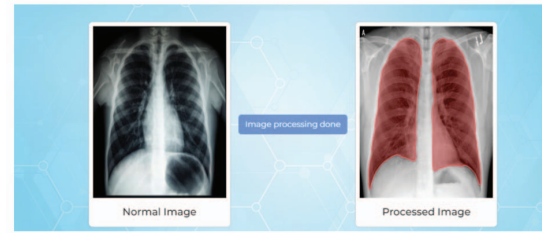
Patient Attachment Processing For Doctor. Before-and-after comparison of a chest X-ray, with image processing highlighting lung areas.
